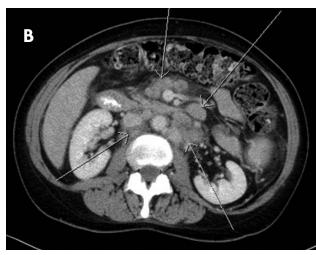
Computed Tomography of patient's abdomen. A. There are diffuse hepatic lesions, a large posterior splenic lesion (arrow), and splenomegaly. B. Diffuse adenopathy can be seen (arrows).
